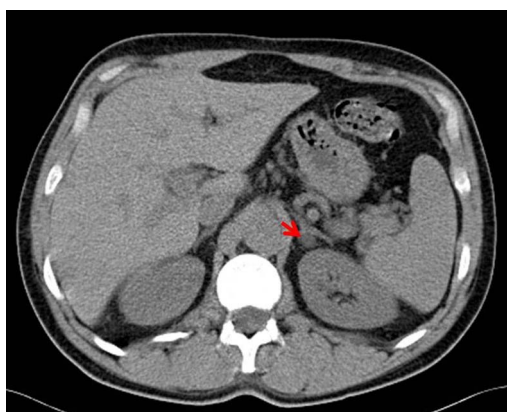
Abdominal CT—axial view: adrenal adenoma (red arrow).
